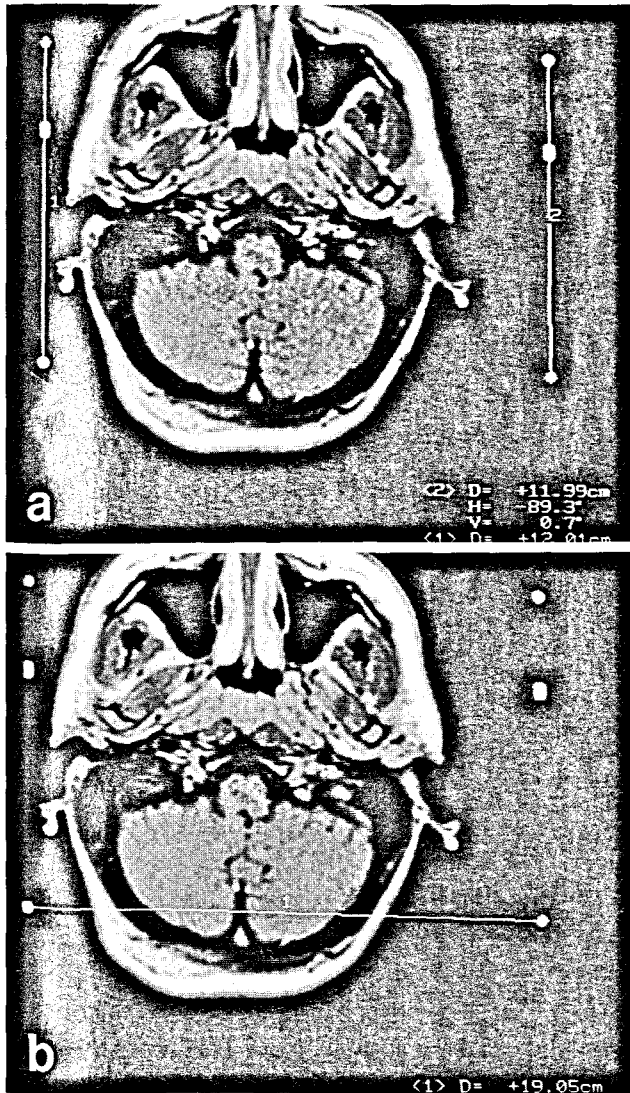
Axial T1 spin-echo MRI studies show distance measurements between the side-plate fiducial markers (A) (actual distance, 120 mm; measured distances, 119.9 and 120.1 mm) and the transverse fiducial markers (B) (actual distance, 190 mm; measured distance, 190.5 mm).
